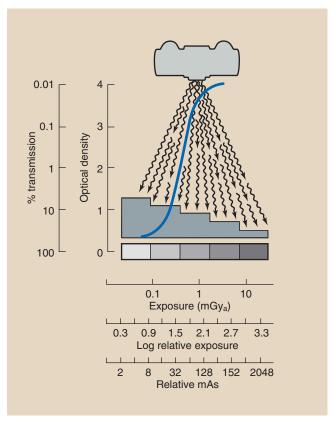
Relationship among log relative exposure (LRE) and relative mAs for typical radiographic screen-film image receptor. Relationship between percentage transmission and optical density (OD) is shown along the y-axis.
